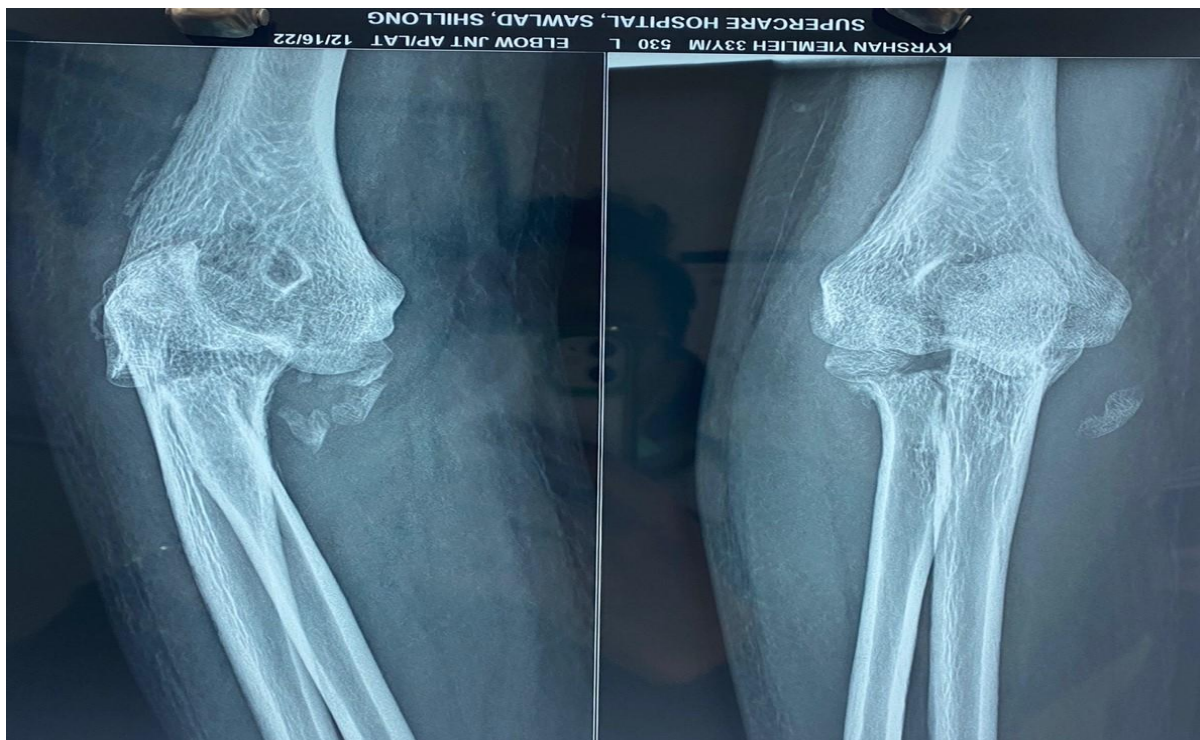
Radiographs showing posteromedial dislocation with fracture radial head, capitellum, coronoid process and distal trochlea. There is heterotopic ossification along humerus
